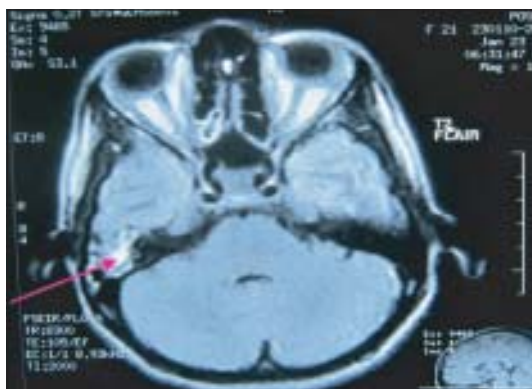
MRI T2FLAIR image showing Right Mastoiditis as showed in arrow head area.
